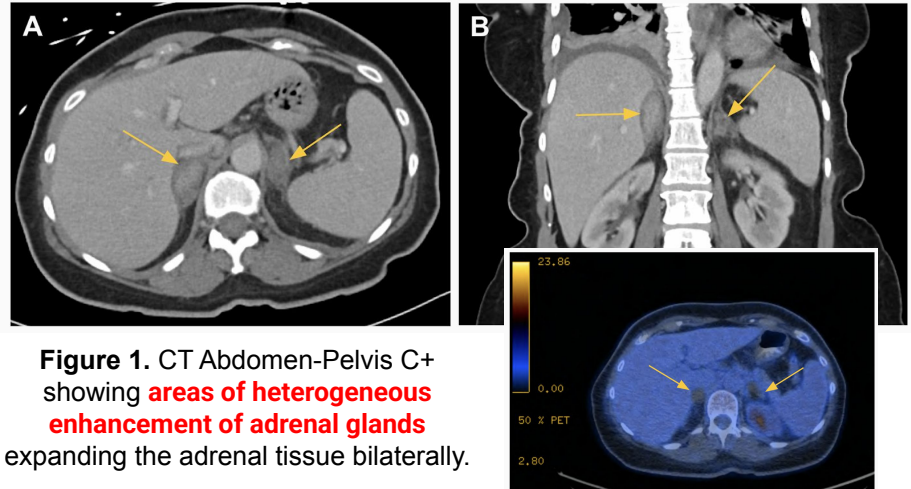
CT Abdomen-Pelvis C+ showing areas of heterogeneous enhancement of adrenal glands expanding the adrenal tissue bilaterally.
